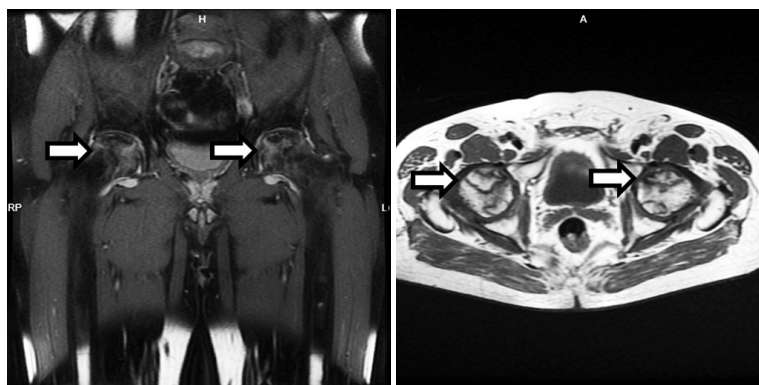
MRI revealing multiple areas of femoral head avascular necrosis (marked with white arrows)
